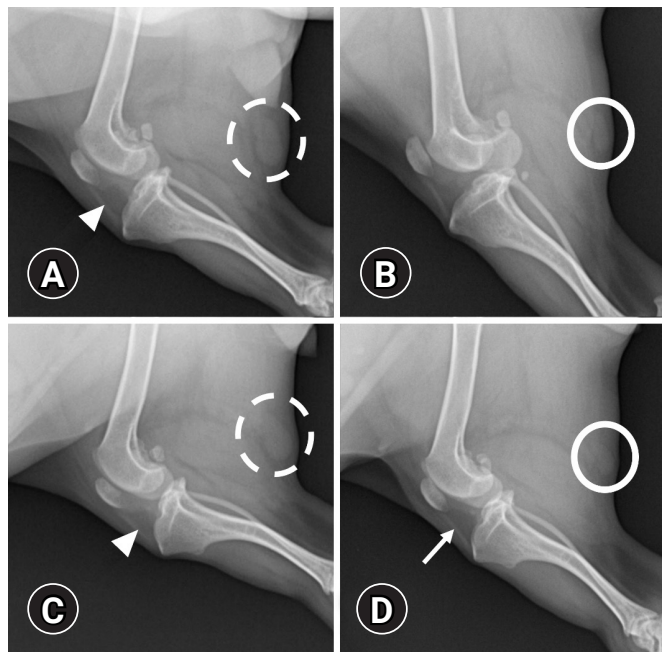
Lateral radiograph of the left (A, B) and right (C, D) stifle joints. (A, C) Before treatment, the radiolucent area behind patella ligament has been reduced without erosive change, showing increased joint effusion (arrowhead). Note the lymphadenopathy in the bilateral popliteal lymph nodes (dashed circle). (B, D) After treatment, the radiolucent area behind patella ligament has been normalized (arrow). And the lymphadenopathy have resolved (circle).
